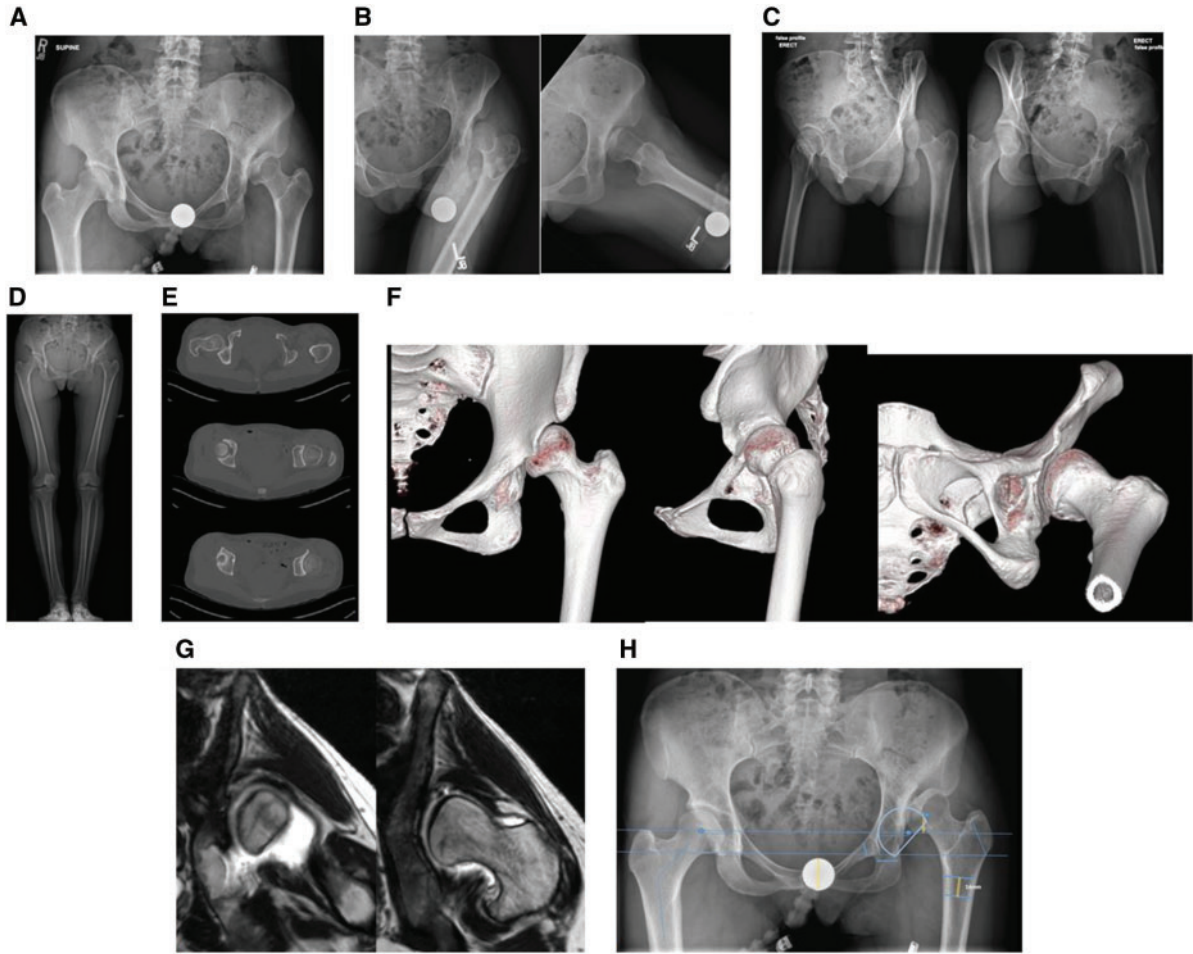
Pre-operative imaging: (A) anteroposterior (AP) pelvis X-ray. (B) Left hip AP and lateral X-ray. (C) Right and left hip false profile views. (D) Bilateral leg-length scanogram. (E) Pelvis CT axial cuts. The calculated femoral anteversion was 9°. (F) Left hip CT 3D reconstructions. (G) Left hip MRI arthrogram demonstrating low hip capsule volume despite high dislocation. (H) AP pelvis with preoperative template for native acetabulum location, trochanteric osteotomy, and possible femoral shortening osteotomy.
